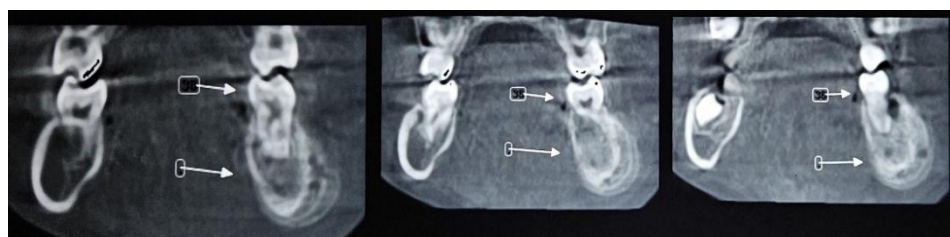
coronal section CBCTview shows thickening of cortical plate
